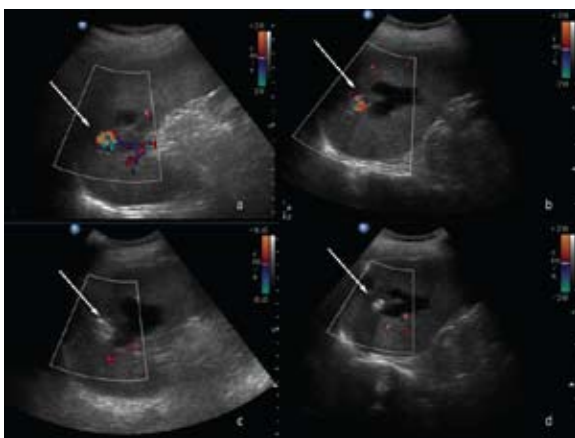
a. Doppler ultrasonography showing the pseudoaneurysm before AE
